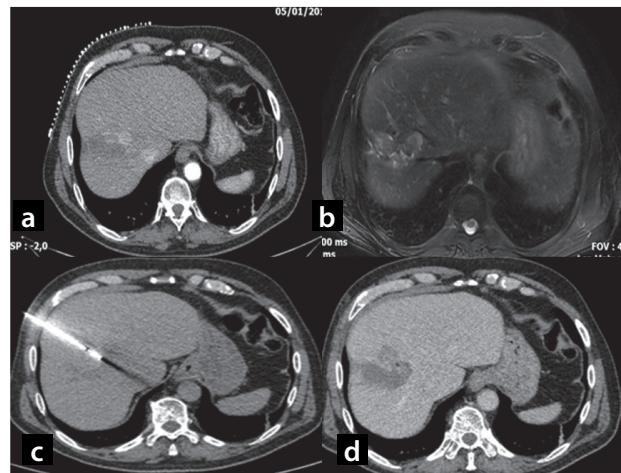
a. Axial CT image of a 65 year-old patient with a new HCC lesion in liver section VIII, close to the primary lesion that was ablated with RF a year before, b. MR image of the same lesion, c. Positioning of the electrode within the hepatic lesion, d. Post-ablation contrast-enhanced CT scan demonstrating the ablation zone and the final therapeutic result.
